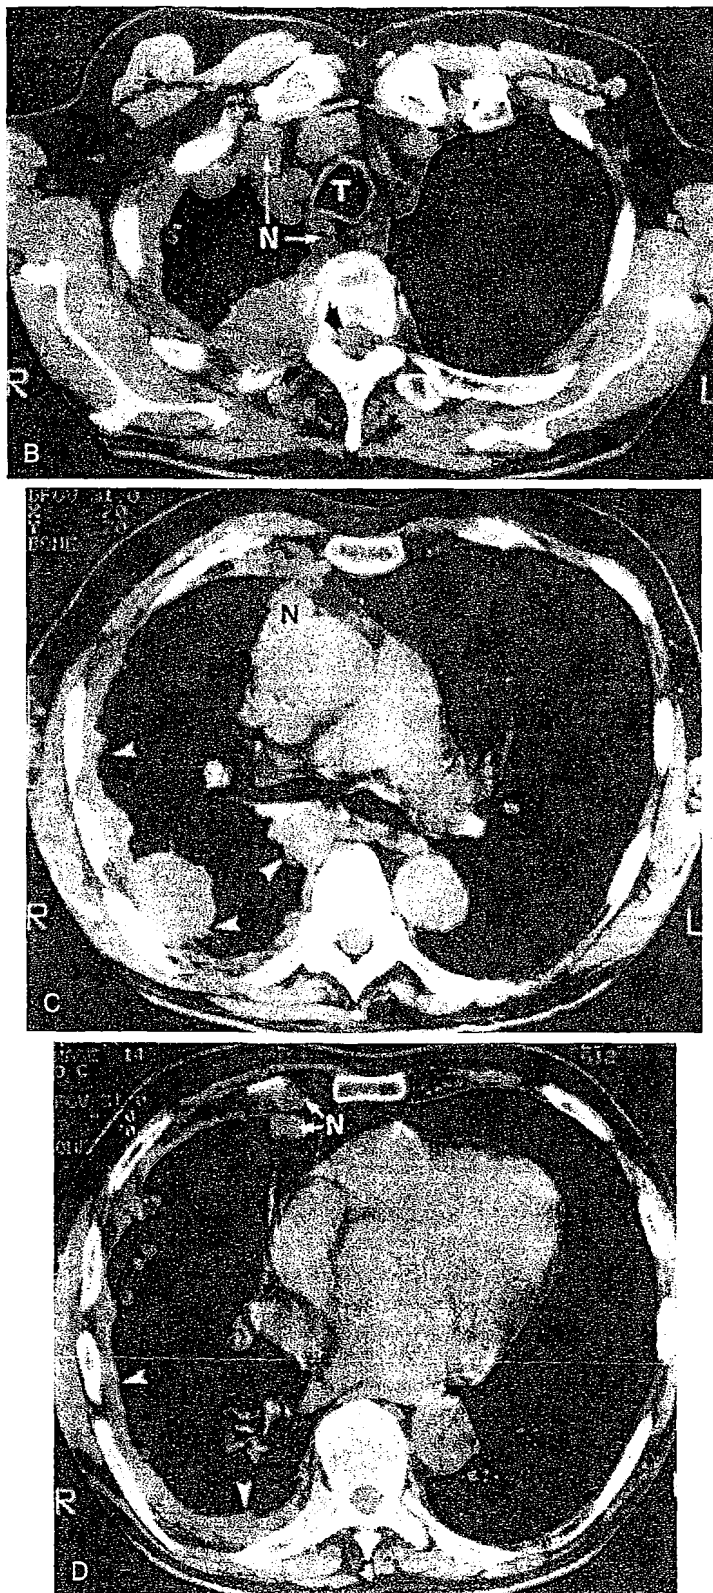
Continued. CT scans through the upper (B), middle (C), and lower (D) thorax confirm the extensive right pleural thickening (arrowheads) and demonstrate extrapleural extension of the neoplasm in and around the ribs and vertebra (closed arrows) and within some of the mediastinal lymph nodes (N). The diagnosis of mesothelioma was confirmed at autopsy several months later.
